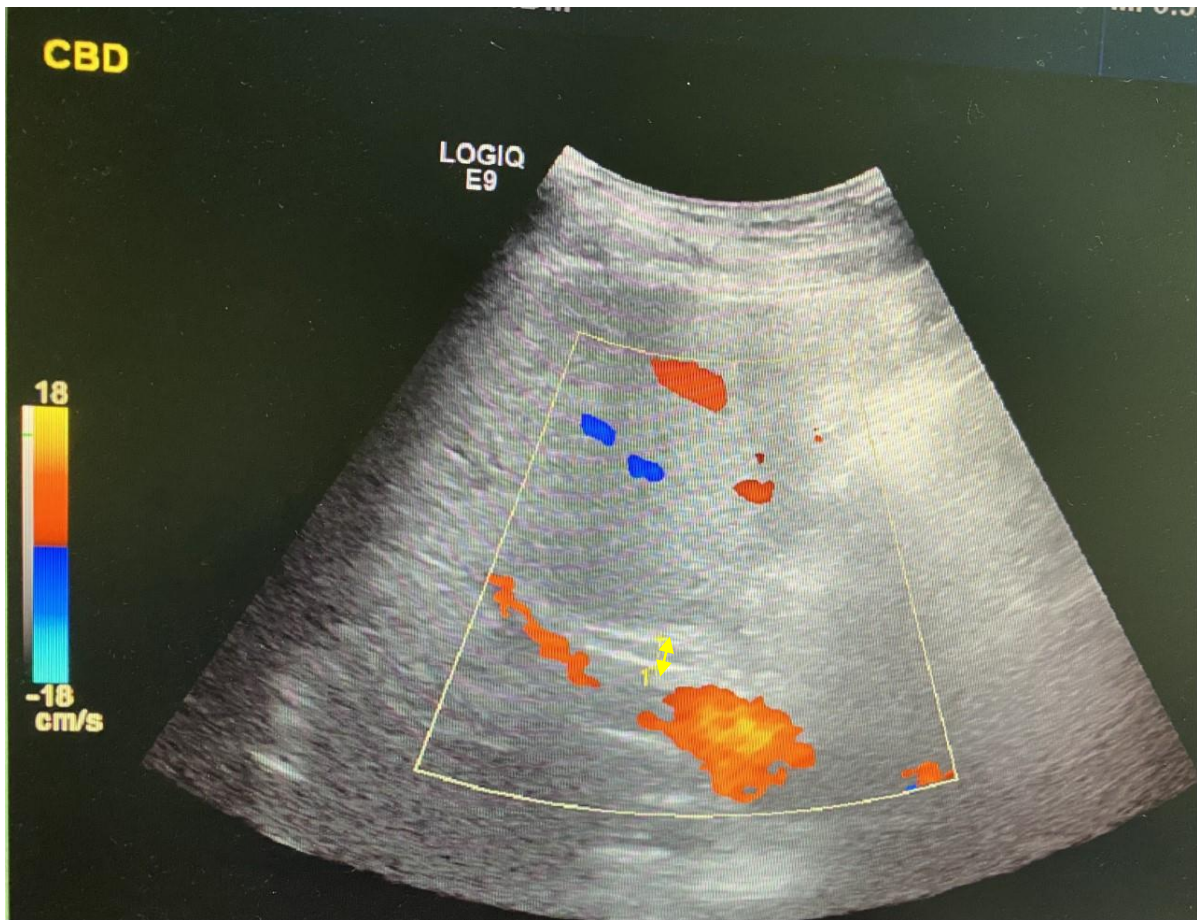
Abdomen Ultrasound showed mildly dilated common bile duct.
